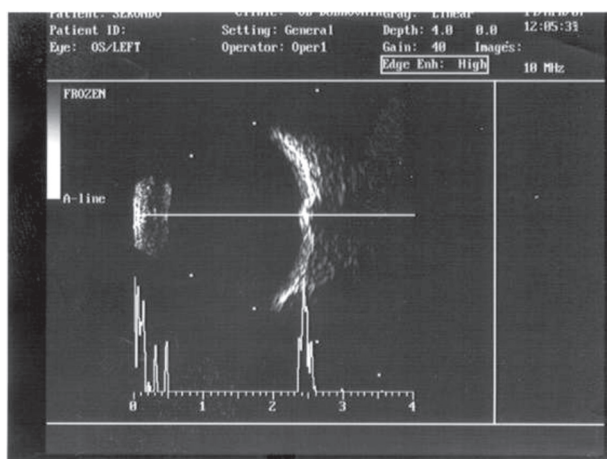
Ultrasonography of buried optic disc drusen.
